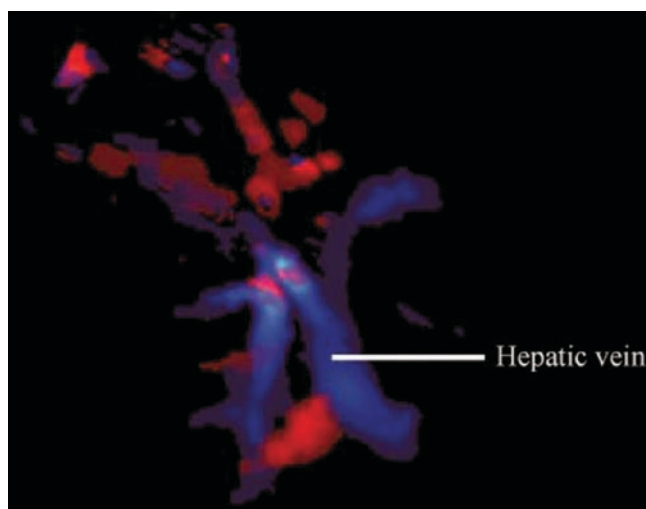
3D color Doppler sonography demonstrates normal fetal liver blood vessels
